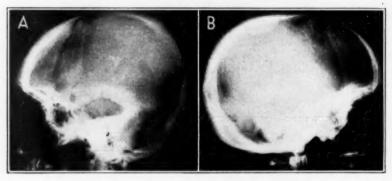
Roentgenograms of the skull, showing abnormal thickness and peculiar aspect of the bone. A, case 3; B, case 5.
